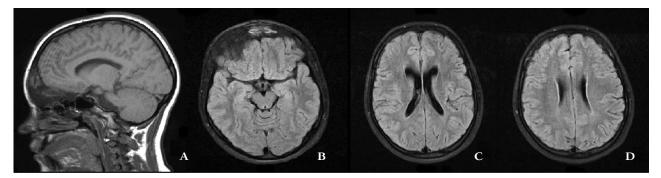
Brain magnetic resonance imagining
